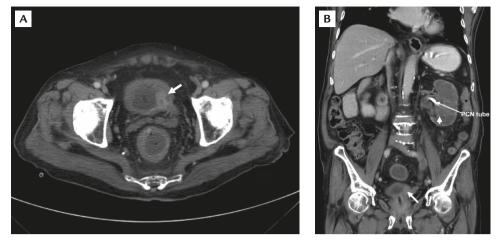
(A) Computed tomography of the pelvis with contrast shows an intravesical mass (arrow) over the internal orifice of the left ureteropelvic region. (B) Computed tomography reconstruction of the abdomen shows severe hydronephrosis of the left kidney (arrow-head) with post-percutaneous nephrostomy drainage (PCN); left hydroureter is also noted. The same intravesical mass (arrow) over the left internal orifice can also be seen.
